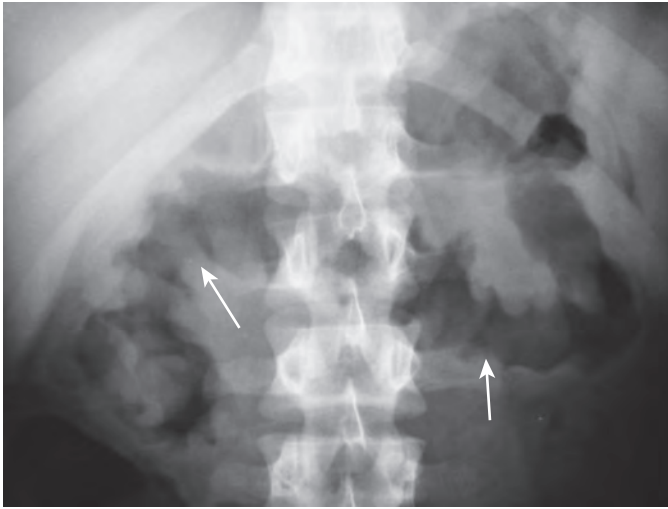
Colonic ischemia: narrowing and thumbprinting on plain abdominal radiograph. Supine radiograph of the abdomen shows marked narrowing and thumbprinting of the transverse colon (arrows) caused by colonic ischemia.
